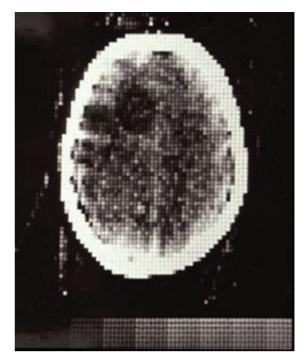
The first clinical CT scan, obtained in 1971. The grainy image shows a brain tumor in a frontal lobe (*left side* of image). Advances in image quality over the last four decades have been dramatic. (*Reproduced with permission from impactscan.org.*)
